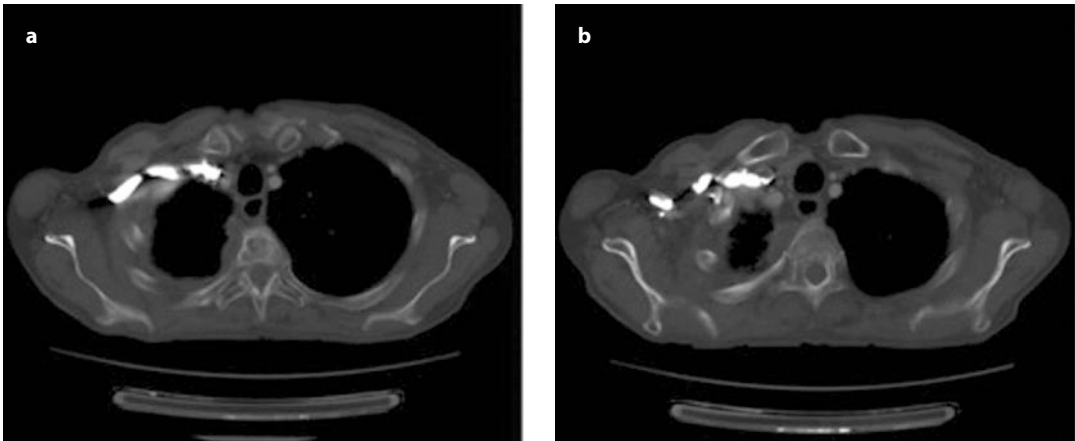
Reevaluation with a CT scan of the patient treated with the planned therapy showed in Fig. 17.1 after 6 months from radiotherapy
